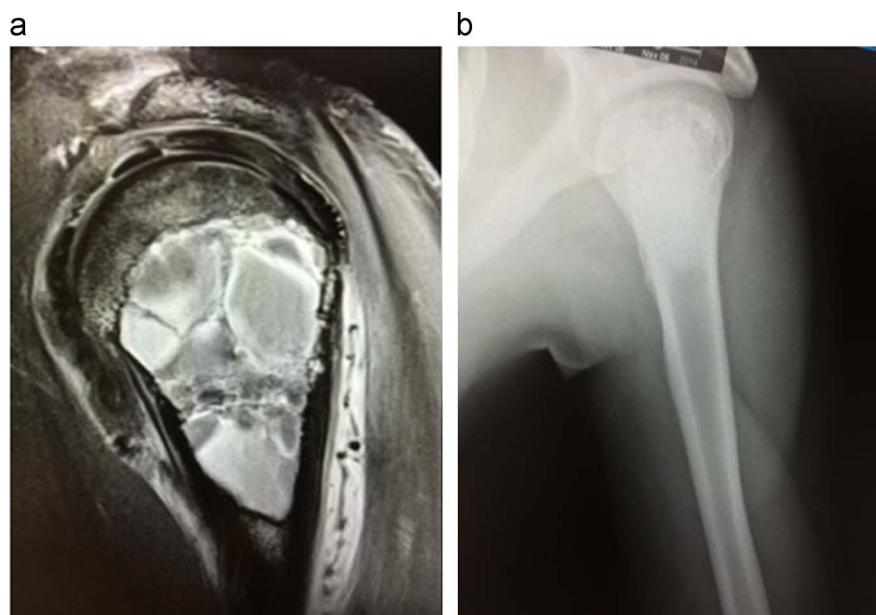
Aggressive chondroblastoma with an aneurysmal bone cyst of the proximal humerus seen on MRI treated with curettage, cryotherapy and bone graft substitute. a) Initial evaluation; b) Post-operative outcome.
